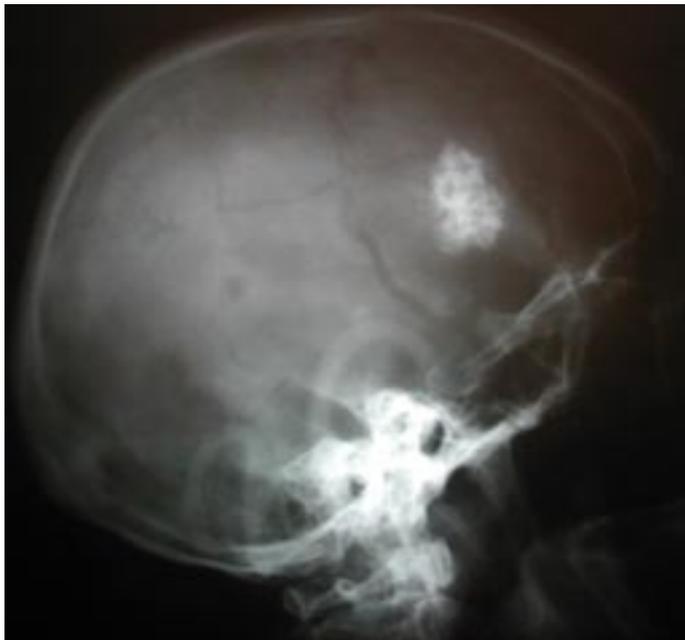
Cranial X-ray shows a frontal calcified lesion.
